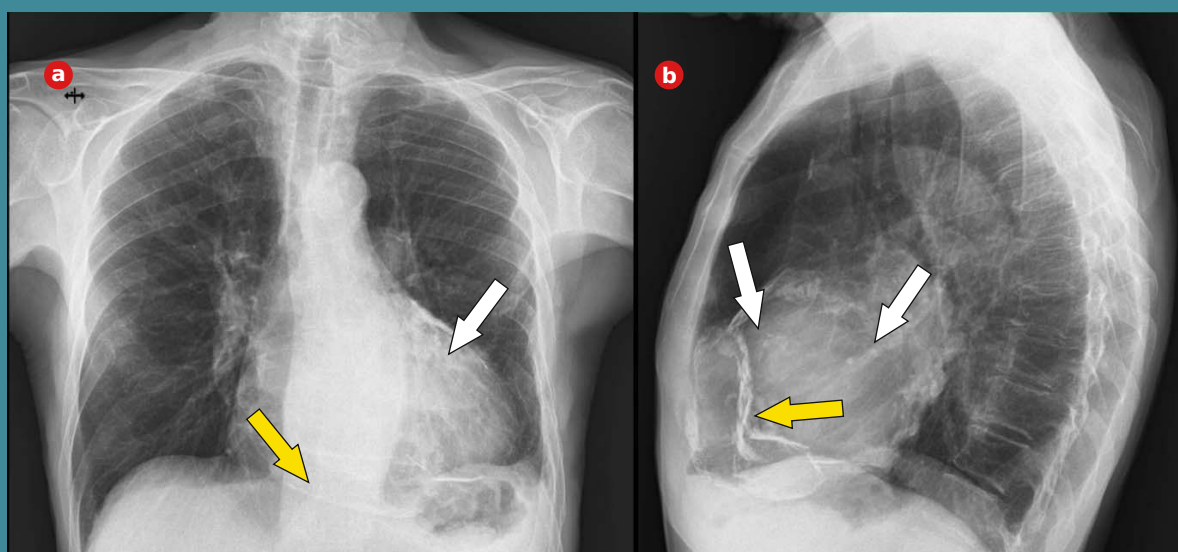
Chest Radiography. (A) Posteroanterior and (B) Lateral view, demonstrating extensive, circumferential calcification of the pericardium (white arrows), creating an "armored heart" appearance. A large, calcified saccular collection is visible precordially (yellow arrows).
